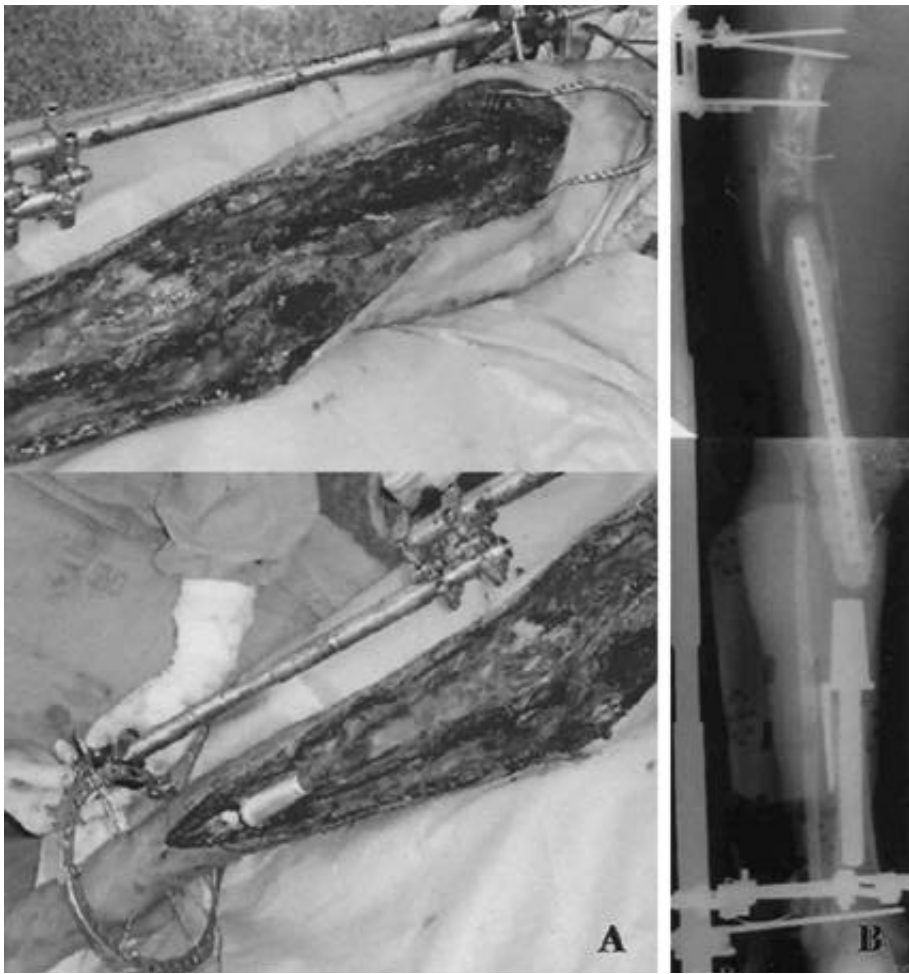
(A) Photographs showing external fixator apply in the operation field of removed infected tumor prosthesis which seen in Figure 1 (C, B) radiograph showed 8 cm lengthening in the 50 days.
